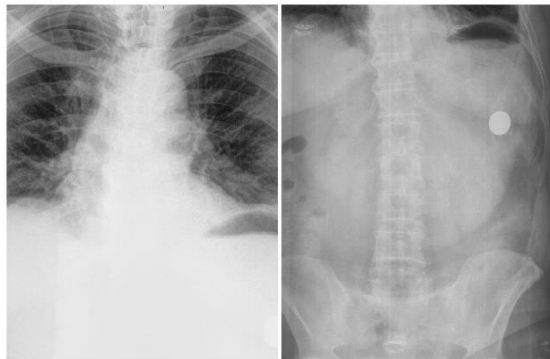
Plain radiograph of chest and abdomen
